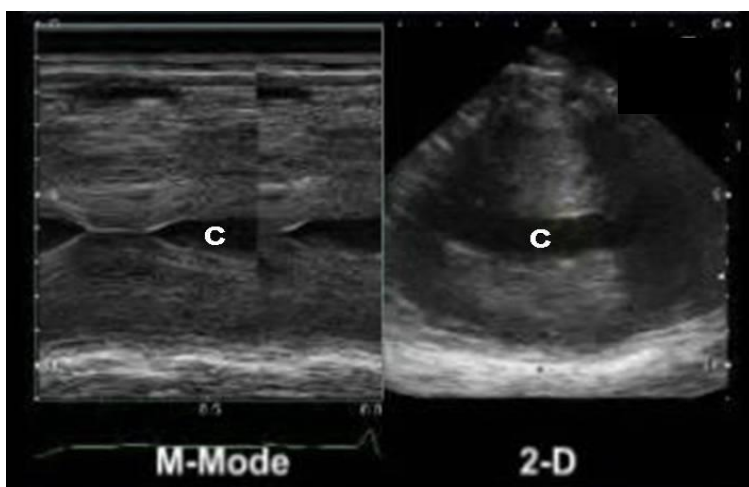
M-mode and 2D echocardiography in a patient with severe hypovolaemia. On the left, at end-systole the ventricular walls come together, and a tiny LV cavity is seen (c). On the right a 2D short axis of the same LV is shown. The calculated left ventricular end diastolic area is $< 5.5 \text{ cm}^2/\text{m}^2 \text{ BSA}$.
